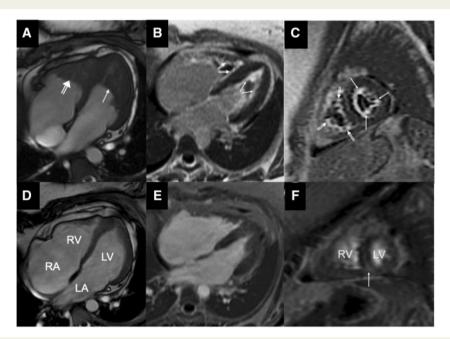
Cardiac magnetic resonance imaging (CMR). (A) Cine image using SSFP sequence, four-chamber view, confirming the left (arrow) and right (double-arrow) ventriculi thrombi. In this view the thrombus occupies half of the left ventricle and most of the right ventricle. Four-chamber, (B) and short-axis, (C) contrast-enhanced images using inversion recovery sequences (normal myocardium is black), showing diffuse subendocardial LGE in left (arrows) and right (double-arrows) ventricles. (Repeat CMR at 11 months: D) Cine image showing no residual thrombus in both ventricles. There is moderate right atrial and tricuspid annular dilatation (moderate TR is evident in the corresponding cine loop in Supplementary material online, *Video S5*). (E and F) No residual thrombus and minimal LGE in contrast CMR using inversion recovery sequences (arrow, showing inferior right ventricular insertion point LGE extending into the mid septum). LA, left atrium; LGE, late gadolinium enhancement; LV, left ventricle; RA, right atrium; RV, right ventricle; SSFP, steady-state free precession; TR, tricuspid regurgitation.
